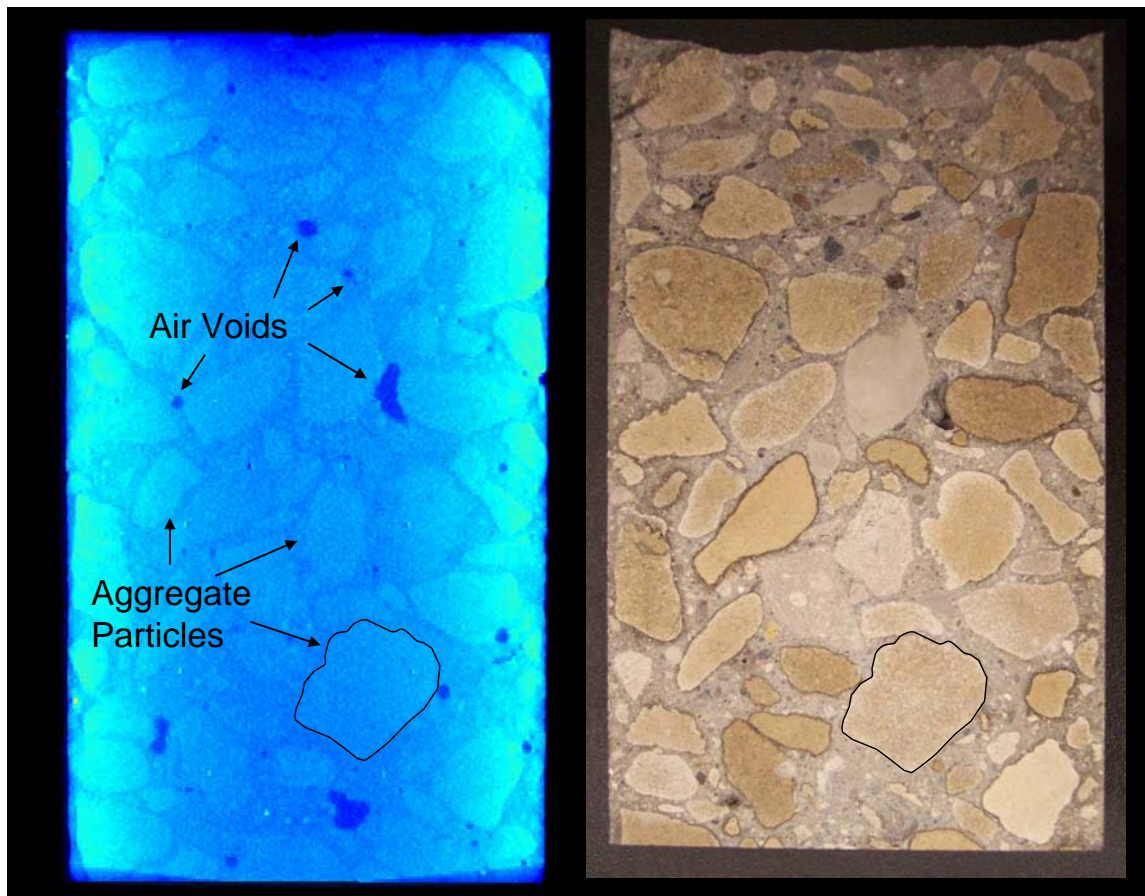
Sample one central profile, CT created (left) and actual saw cut (right)
